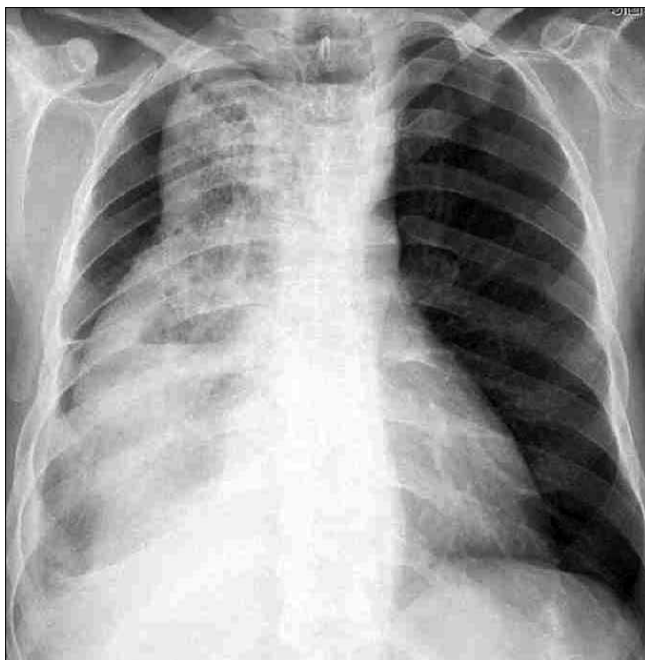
Chest radiography shows a massively dilated esophagus filled with food residue and multiple air bubbles.
